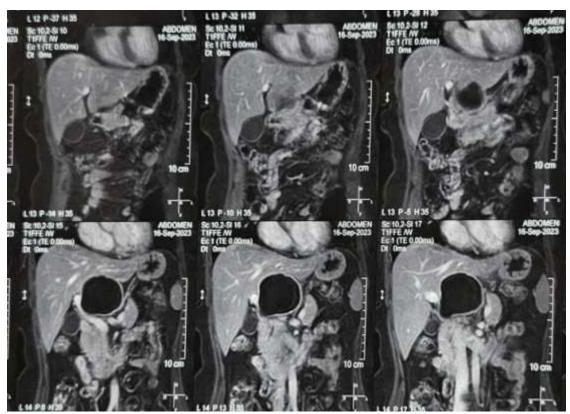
MRI Image showing cystic lesion in caudate lobe of liver, with mildly enhancing membrane/ septa within the lesion with abutment of left portal vein inferiorly and laterally, however portal venous flow appeared normal. Lesion was posteriorly abuting IVC.
